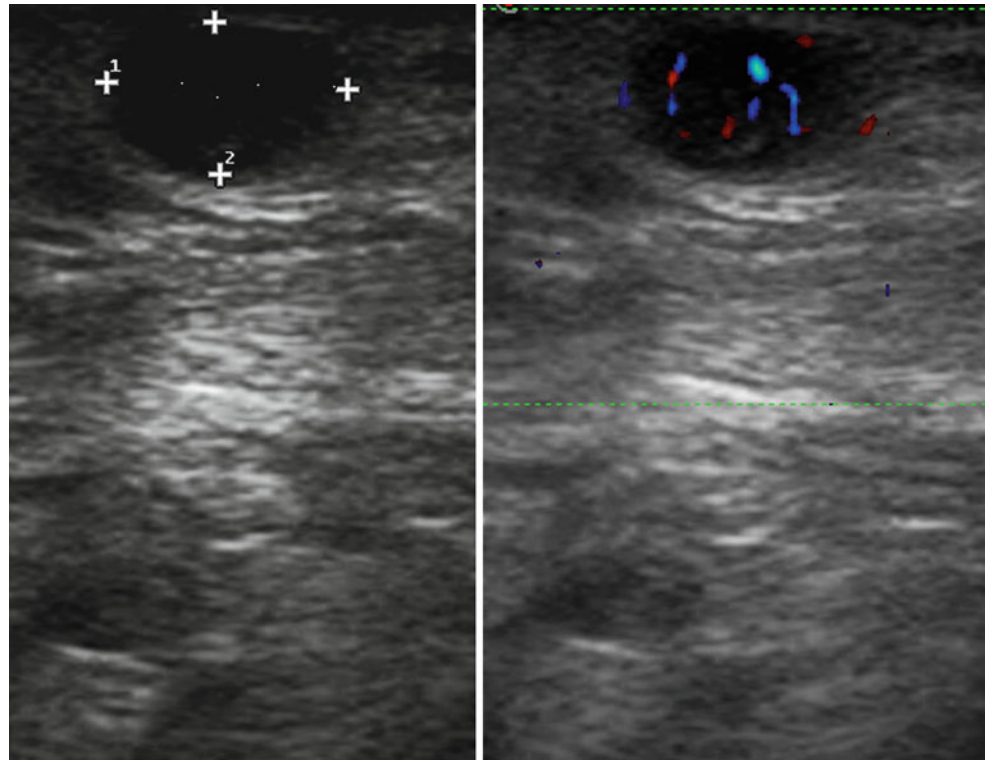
Cutaneous metastasis of the chest. Directional power Doppler image shows flat hypoechoic nodule with intense vascularization
